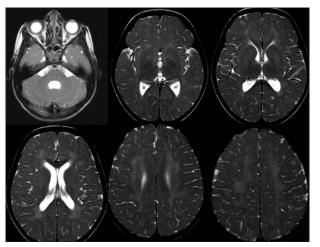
T2WI axial images of MRI brain shows mild diffuse cerebral and cerebellar atrophy with prominence of ventricular system, white matter hyperintensities and hypointensity in bilateral lentiform nuclei (indicates calcification)
